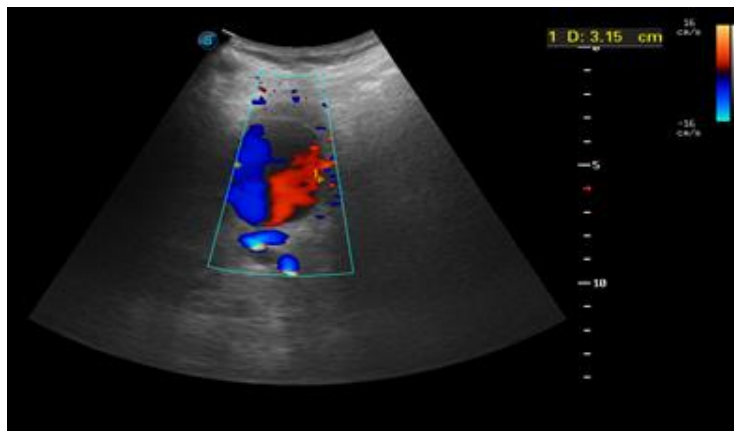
Ultrasonographic finding in the hilum of the liver.
